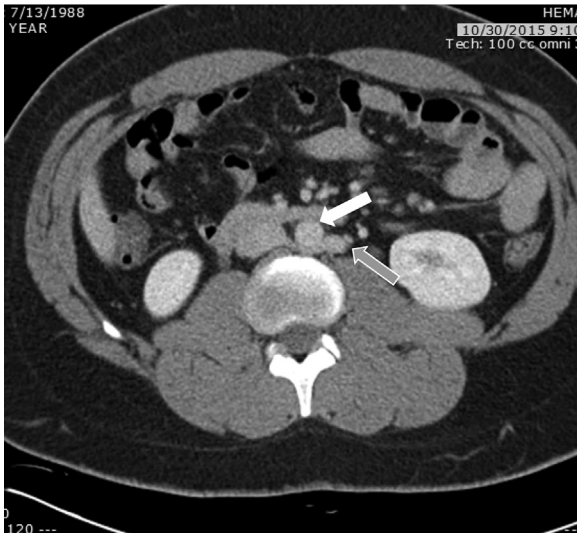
Axial view of computed tomography venography demonstrating a retroaortic (*white arrow*) left renal vein (LRV; *gray arrow*).
